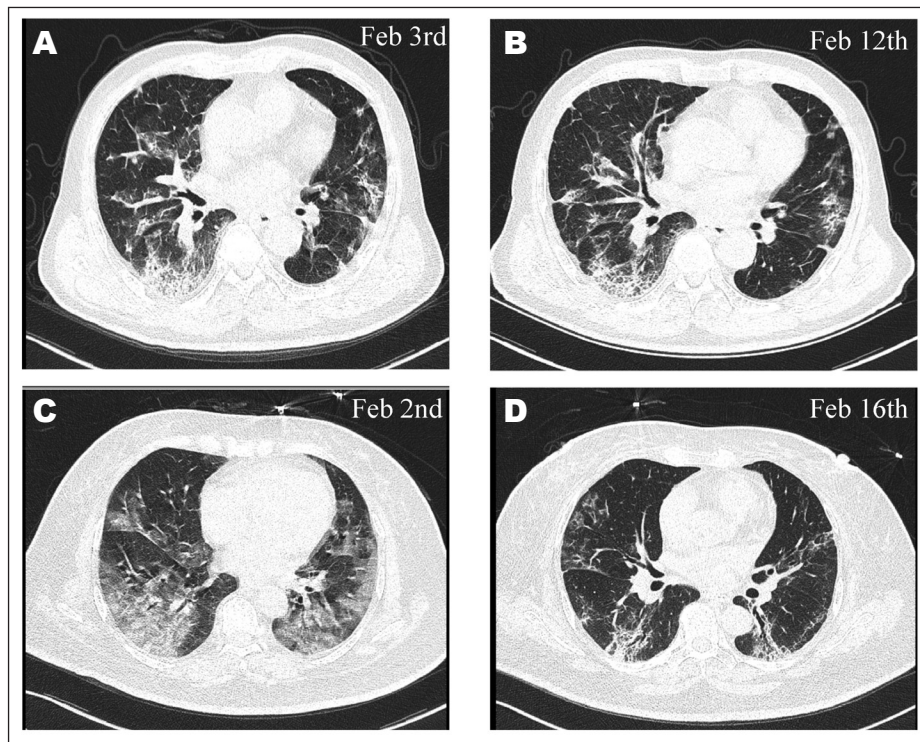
A and B, indicate the lung CT of a discharged non-ICU patient. C and D, indicate the lung CT of an improving non-ICU patient. CT = computed tomography; ICU = intensive care unit.
